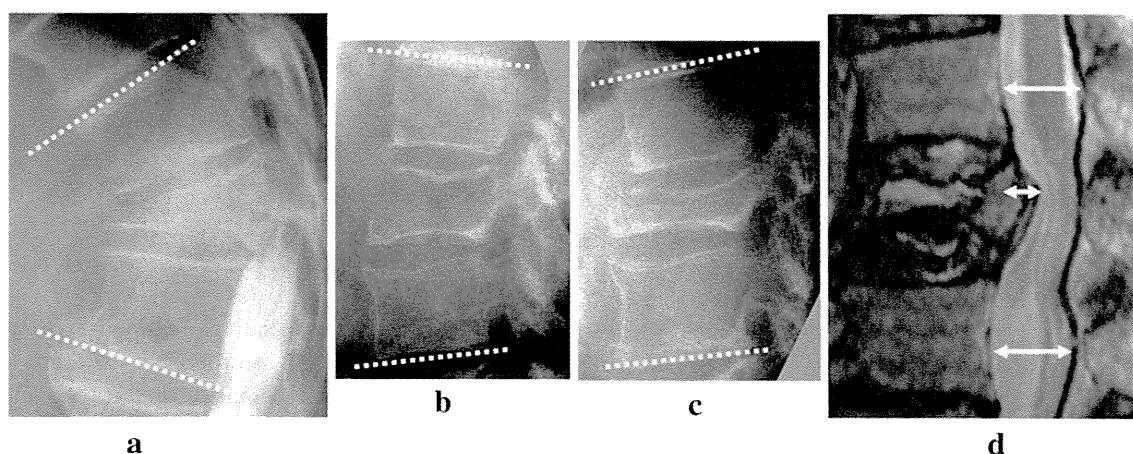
Radiological assessment. a Local kyphosis was calculated as Cobb angle between the upper endplate of the vertebra just cranial to the fractured vertebra and the inferior endplate of the vertebra just caudal to the fractured vertebra on lateral plain X-ray films. b, c Angular instability was calculated as change in Cobb angle on
